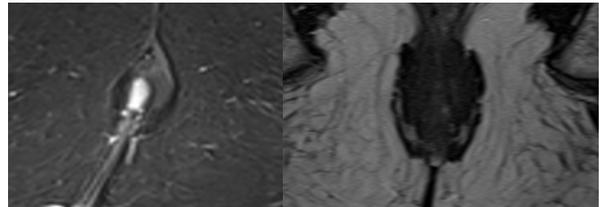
MRI STIR And T2 Images Show Low Intersphincteric Fistula.
